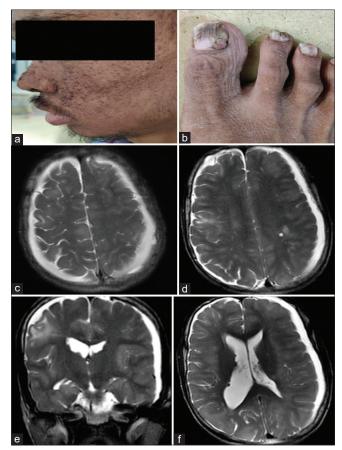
A 33-year-old male with tuberous sclerosis. The patient had facial adenoma sebaceum (a) and multiple periungual fibromas (b). (c) MRI brain T2W image shows presence of multiple T2 hyperintense cortical tubers. (d and e) MRI brain T2W image shows presence of white matter heterotopias extending from ventricles to cortex. (f) Small subependymal nodules can be noted in bilateral lateral ventricles
